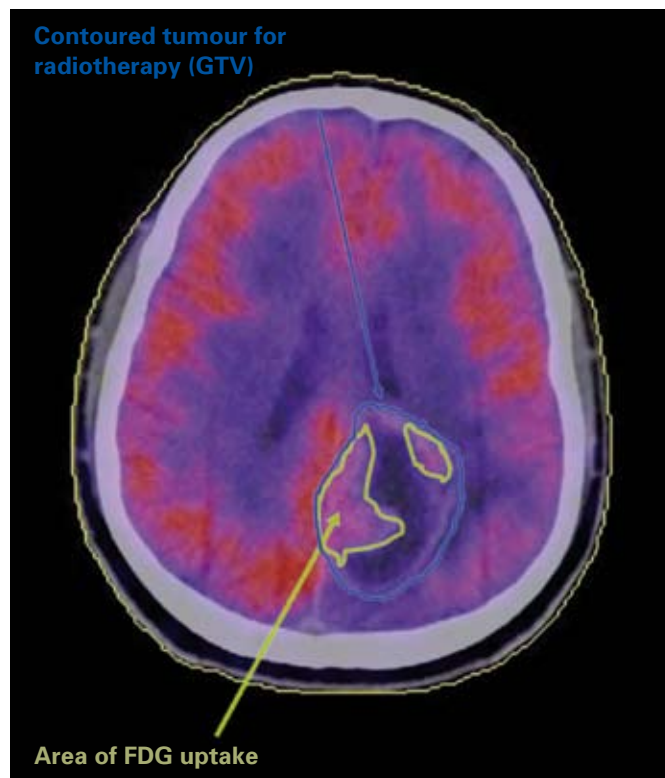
Glioblastoma. Axial view of  $^{18}\text{F}$ -FDG PET-CT with contrast. The area of the post-operative tumour volume for radiotherapy is defined in blue. Yellow areas are the areas of FDG uptake. Volumes are usually within the contrast enhanced area of CT and MRI. The normal brain shows high uptake of FDG in general and makes a clear distinction between tumour and normal brain difficult.
